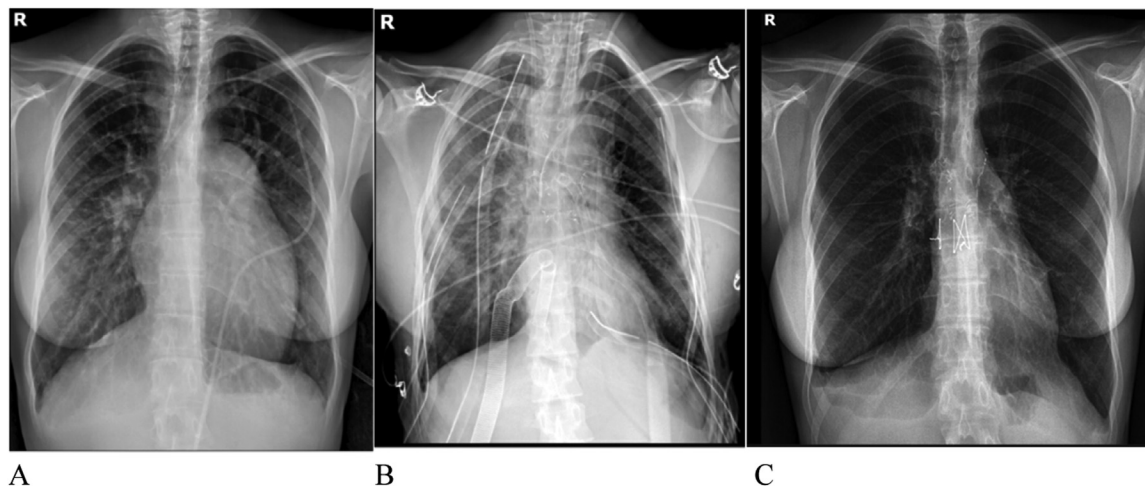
(A) Chest X-ray before lung transplant, (B) Chest X-ray 1 day after lung transplant (note extracorporeal membrane oxygenation cannulae), and (C) Chest X-ray 10 months after lung transplant.
